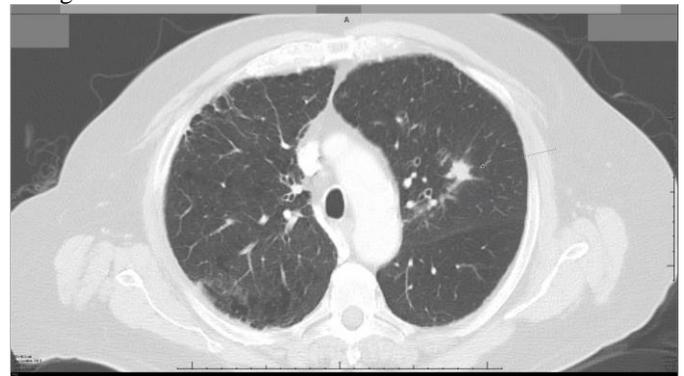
Chest CT four months after the initial study showing a slight increase in the size of the nodule to 19 x 12 mm.
